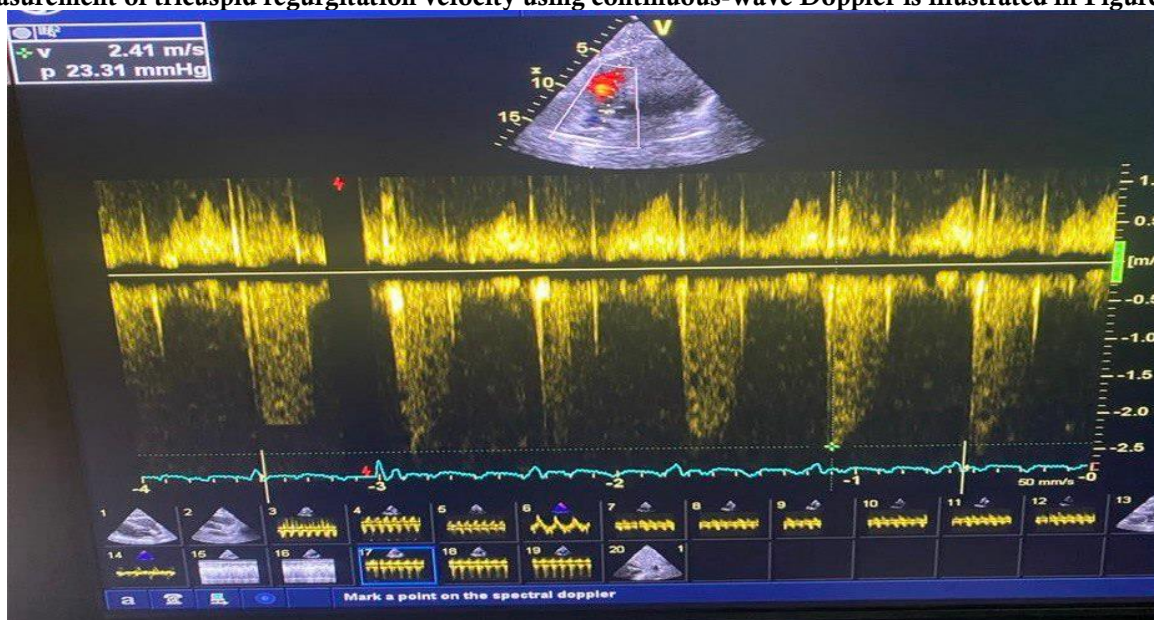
Measurement of Tricuspid Regurgitation Velocity Using Continuous-Wave Doppler
